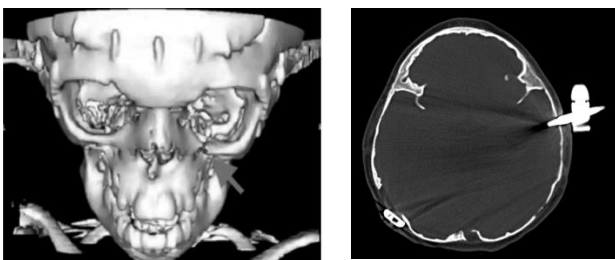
A) 3D reconstructed CT scan showing a post-operative zygomatic-maxillary fracture (red arrow) due to distraction in a patient with Crouzon's syndrome. B) Axial CT showing an intracranial migration by pin in an external device during the distraction process.
